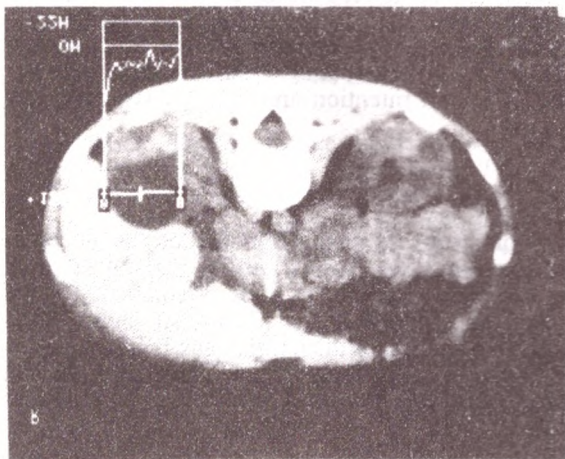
CT demonstrating PKD.
